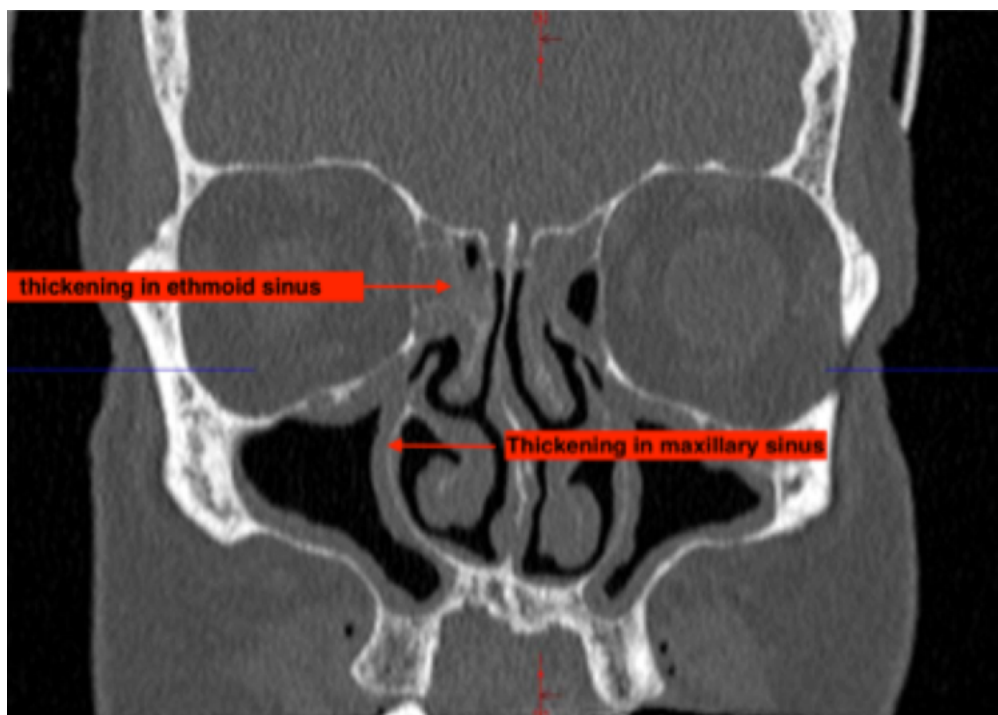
A CT scan showing significant sinus thickening
